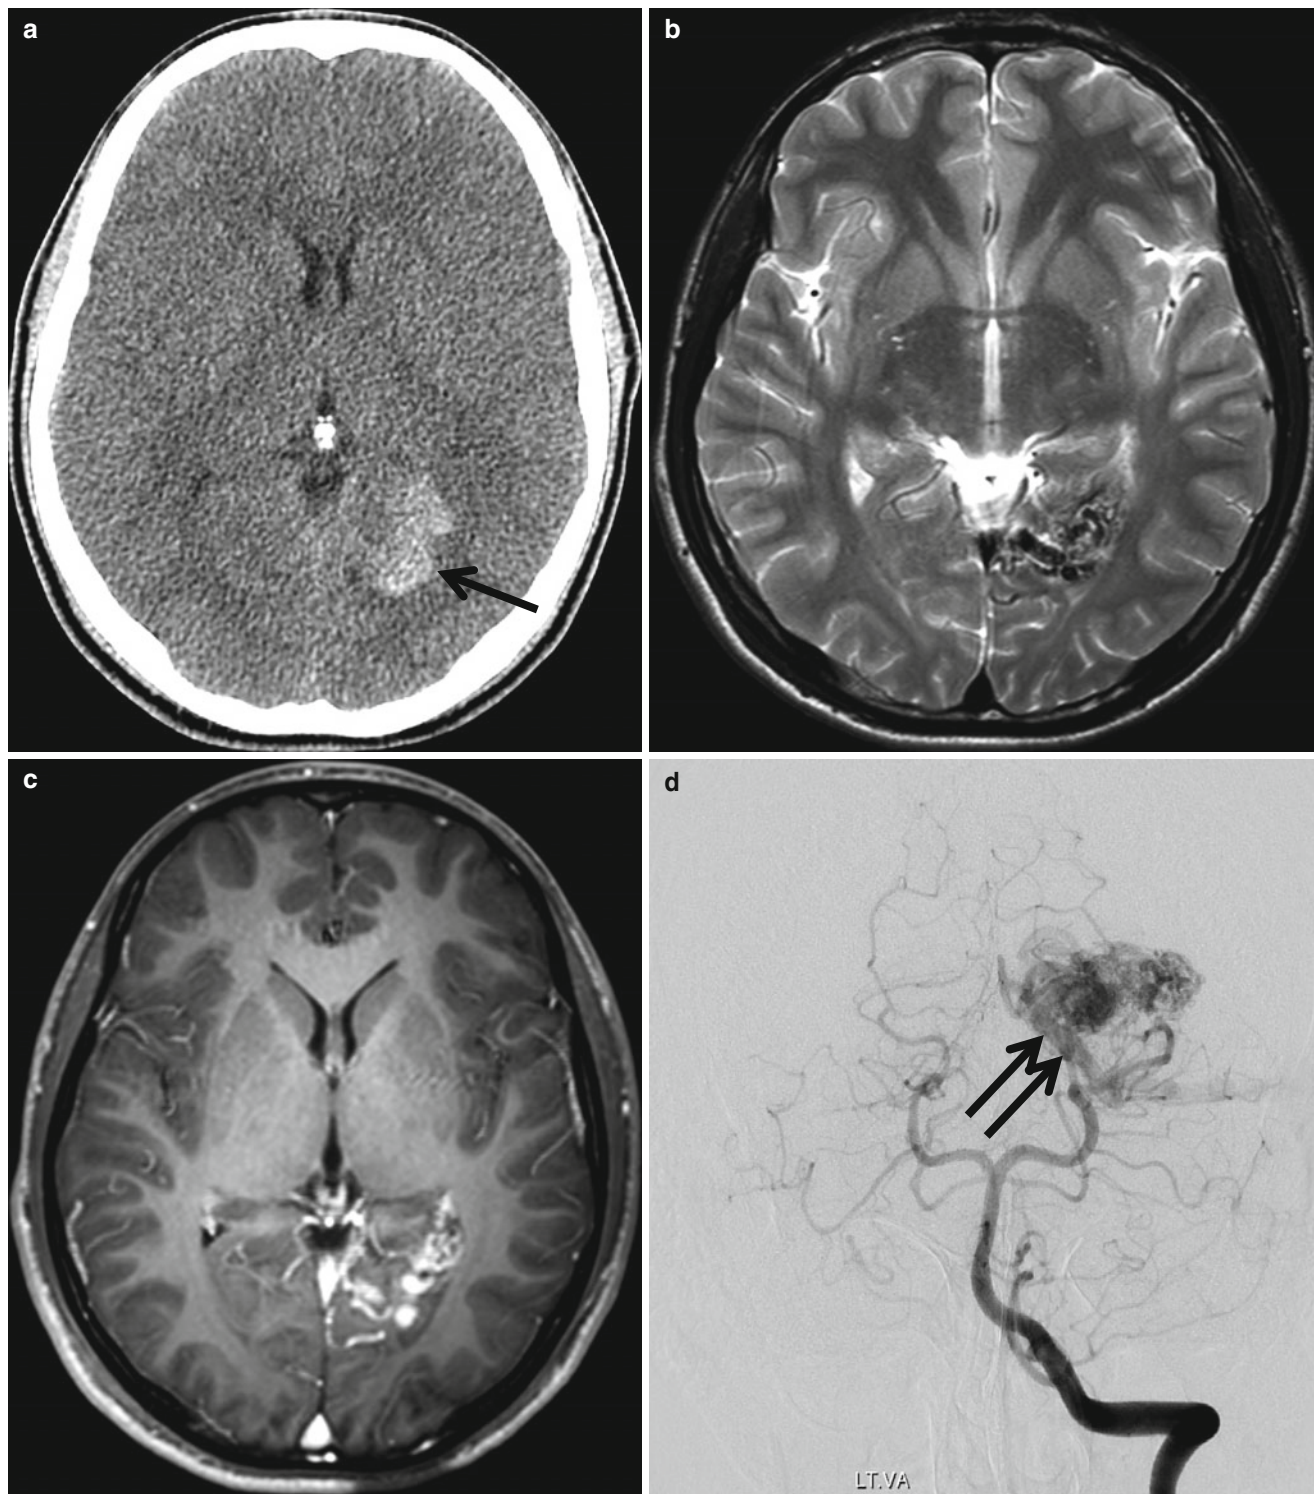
ICH associated with AVM. (a) CT scan shows hyperdense hemorrhage (*arrow*) in the left occipital lobe. (b) T2-weighted image shows signal void entangled vessels at the same area. (c) Dilated
